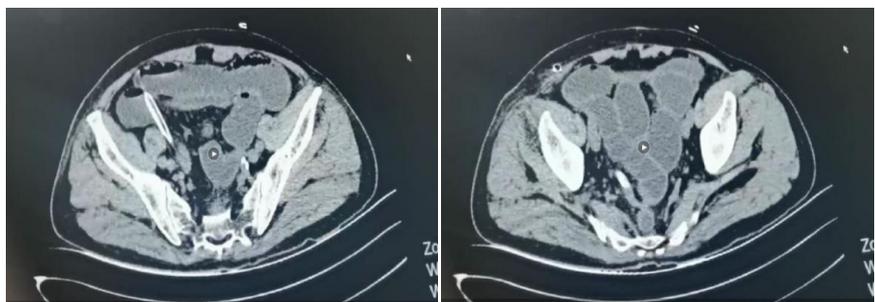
Abdominal CT image on the third day after rectal cancer surgery.
